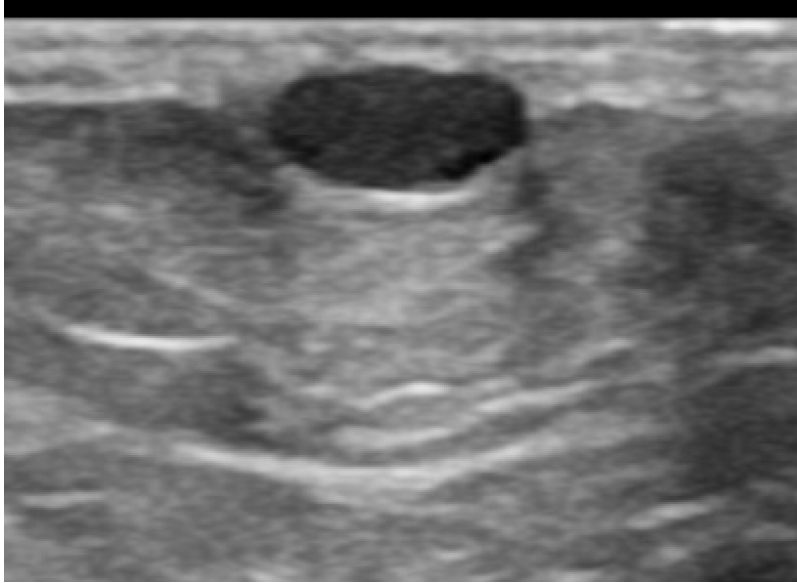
B-mode grayscale targeted ultrasound of the right breast in the sagittal plane demonstrates an irregular mass with indistinct margins, hypoechoic. Color Doppler is evidenced by the yellow rectangle, and there is no internal vascularity. Duct changes are noted. Pathology showed low-grade invasive ductal carcinoma.
